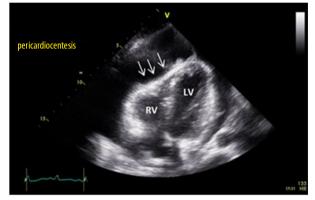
Four-chamber apical view of transthoracic echocardiogram showing early diastolic collapse (arrows) of the right ventricular (RV) free wall surrounded by a large pericardial effusion.
